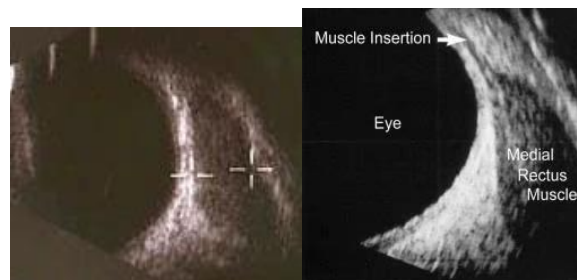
B-scan ultra-sonogram reveals enlargement of the extraocular muscle belly. The tendinous insertion of the extraocular muscle at the globe is not thickened, which is characteristic of thyroid-related orbitopathy.
